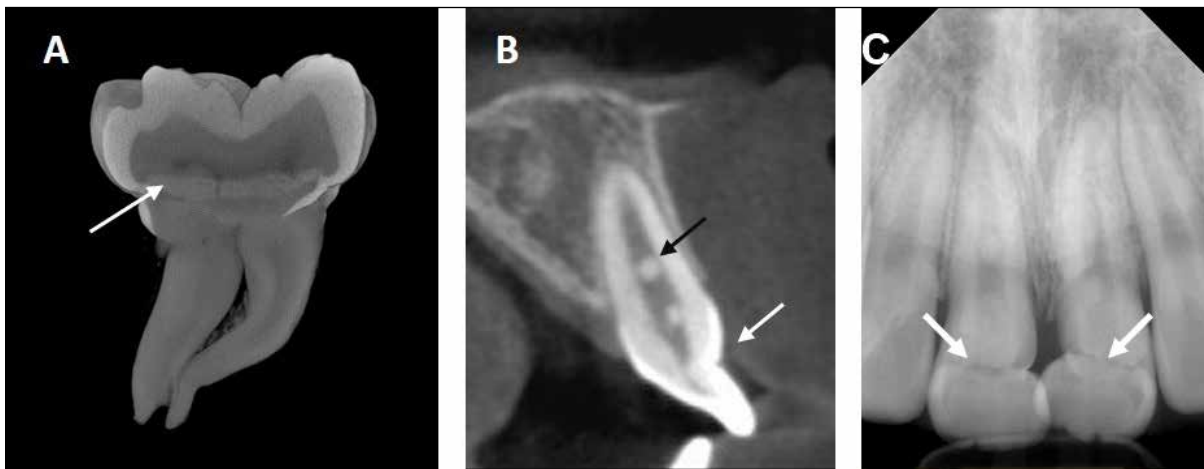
Case 1. (A) Sagittal section of the Micro CT image. Extracted lower right first permanent molar exhibiting cervical mineralized diaphragms (white arrow). (B) Sagittal section from the CBCT showing pulp stones of the maxillary central incisor (black arrow), labial curvature, and wedge-shaped defects (white arrow). (C) Periapical radiograph showing the MRIM affected maxillary central incisors. The white arrow indicates a wedge-shaped defect on the one-third portion of the crown.
